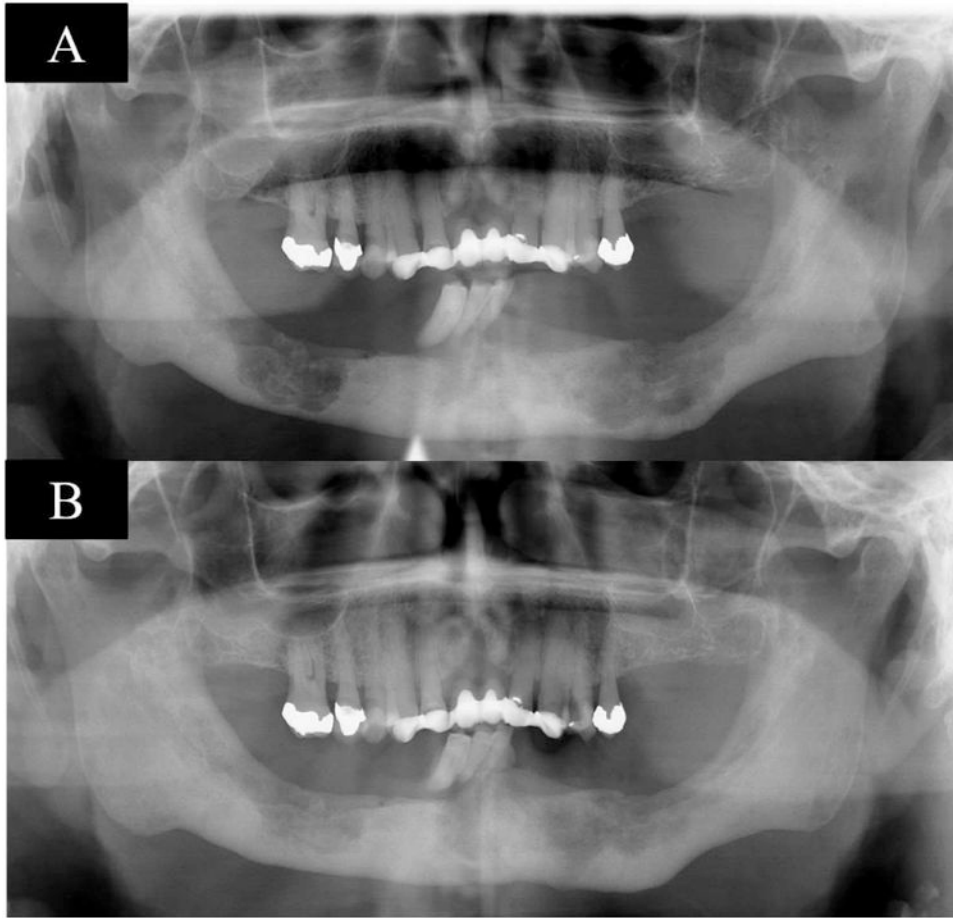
shows pre-therapy panoramic radiograph with bilateral radiolucent defects (A), panoramic radiograph shows bilateral radiographic bone fill after 11 months of therapy (B), case 2
